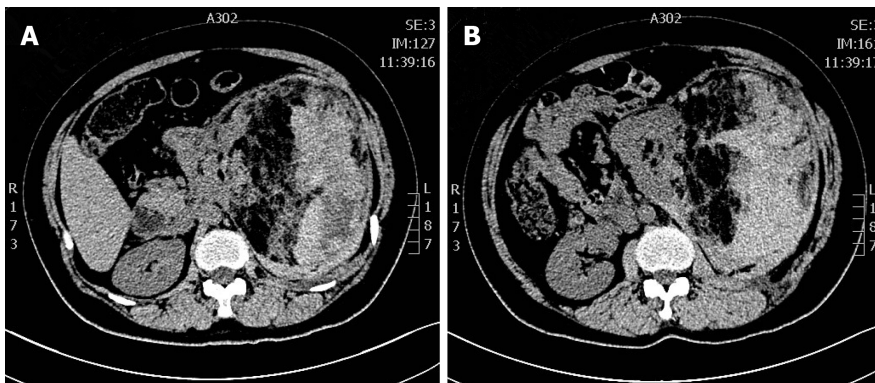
Computed tomography exhibited a large, mixed-density mass in the left kidney. The density of the area adjacent to the kidney was low (A), and the area far from the kidney showed high density (B).
